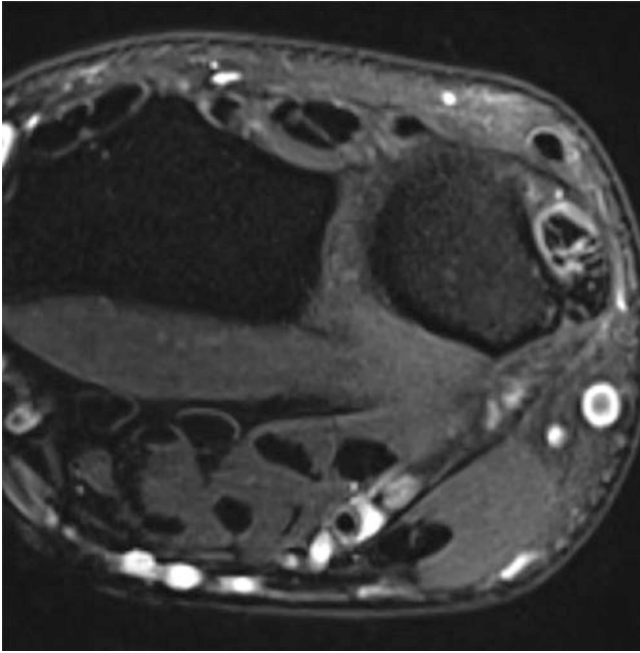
Fluid-sensitive MRI images through the wrist demonstrate tendinosis and mild tenosynovitis of extensor carpi ulnaris with a superimposed partial thickness longitudinal tear
